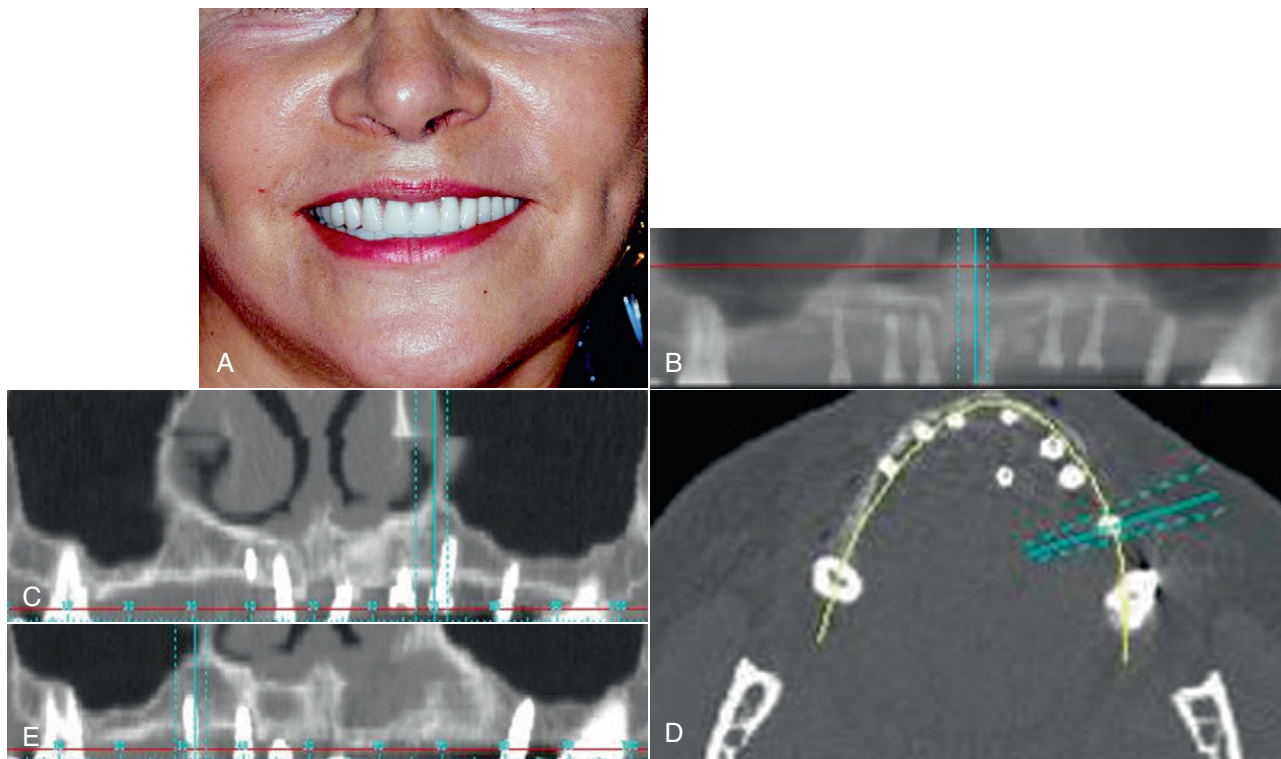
A, Facial view of the finished case the day of delivery. B, Finished case after 4 months. The CT scan shows the implants in place. Lateral views (C and E) and sagittal view (D).
